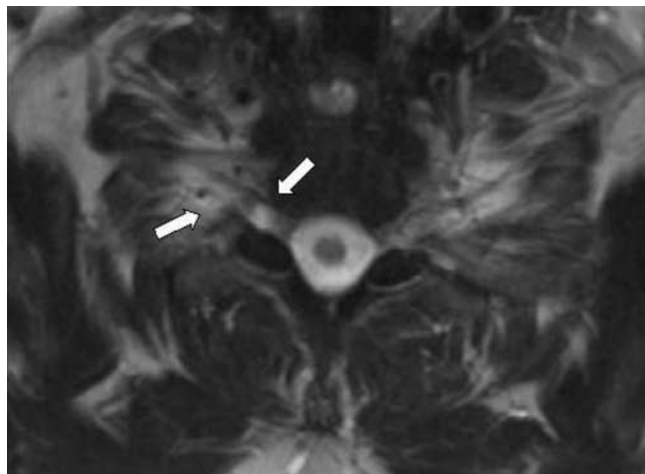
Contrast-enhanced axial MR images of the cervical spine show an arachnoid cyst of the third cervical root suggesting the presence of a dural leakage (arrows)
